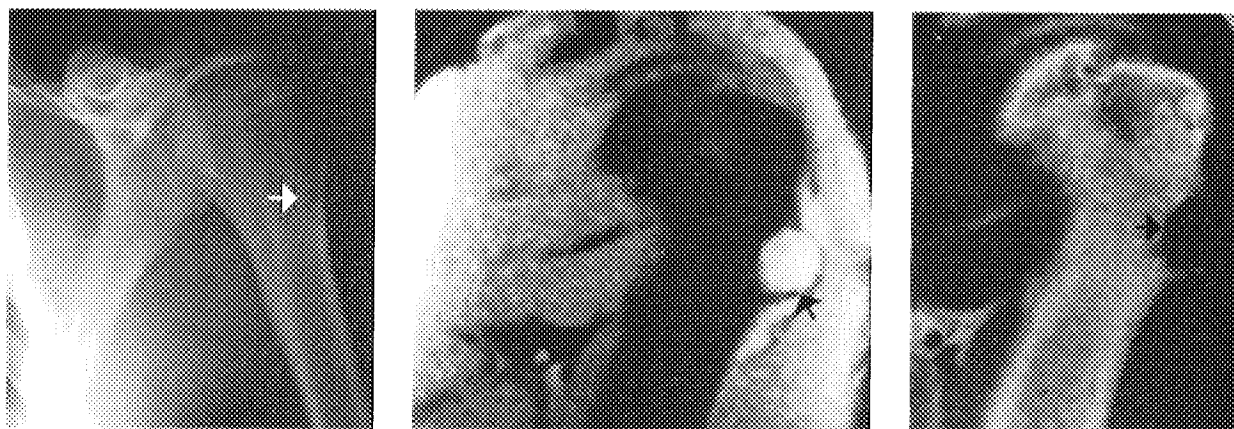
Left, AP radiograph of a 22-year-old man with pain in the shoulder shows a surface lesion (arrow) of the proximal part of the humerus laterally. Center and right, The lesion (arrows) as it appears on coronal T2-weighted and T1-weighted MRIs of the involved area. These studies were interpreted as showing periosteal chondroma. After confirmation on frozen section of a benign cartilaginous lesion, simple resection was performed and was curative.
